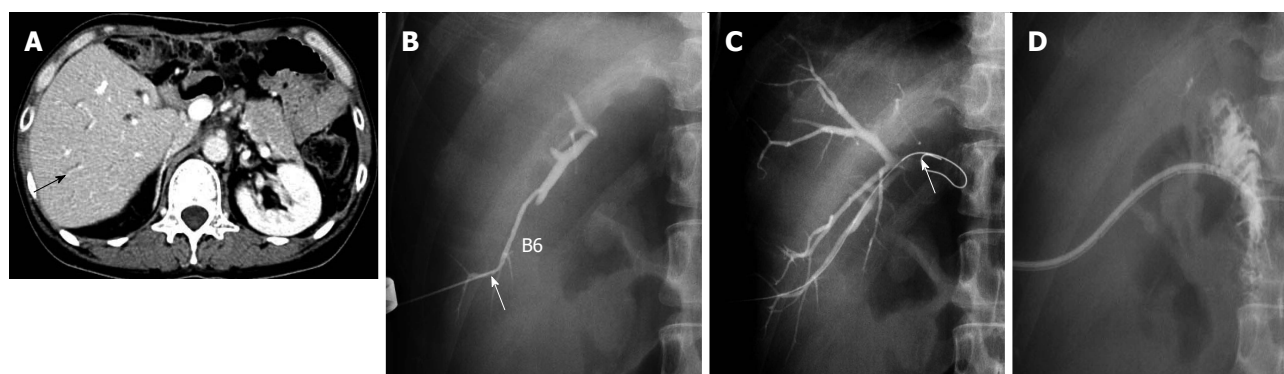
A 57-year-old man who had undergone living donor liver transplantation with right posterior sectional graft 8 mo earlier presented with recurrent cholangitis due to stricture of the bilioenteric anastomosis. A: Computed tomography shows that the intrahepatic bile duct (BD) is not dilated. The arrow indicates a peripheral branch of B6; B: Under ultrasonographic guidance, a non-dilated peripheral branch of B6 is punctured along its running course with a 21-G needle; C: While controlling the needle tip, a 0.018-inch guide-wire (GW) is inserted carefully into the BD; D: When the hydrophilic 0.035-inch GW crosses the anastomotic stricture, a 7-Fr catheter with distal curve crosses the stenotic bilioenteric anastomosis and advances into the jejunal loop.
